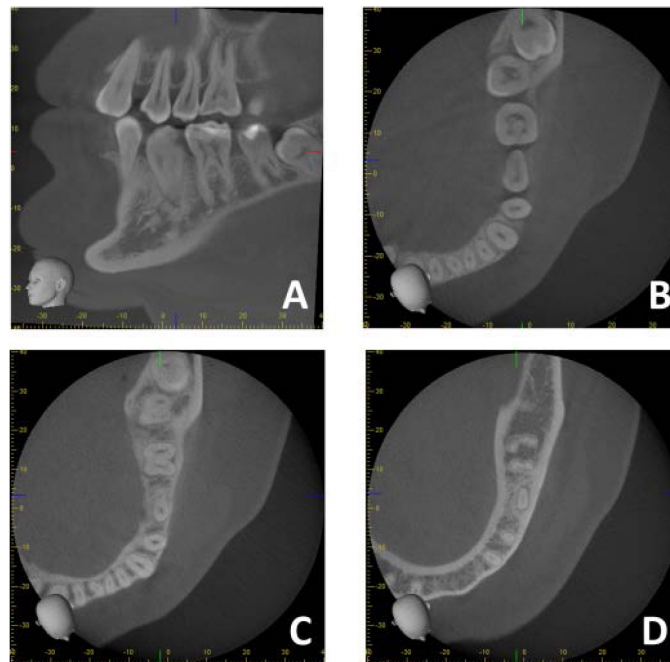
CBCT images of the mandibular left second premolar. A- sagittal view, B- axial view at the coronal one-third of the root, C- axial view at the middle one-third of the root, and D- axial view at the apical one-third of the root.
